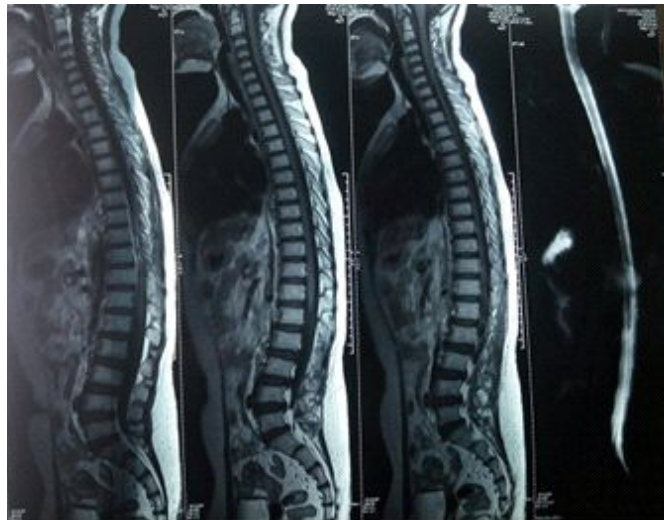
Whole spine MRI with contrast
